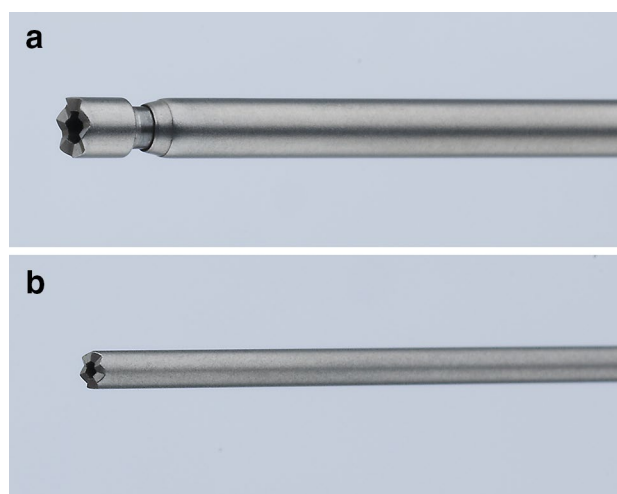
a Tip of Calcuson® lithotripter ultrasound probe with movable portion. b Tip of Calcuson® lithotripter ultrasound probe without movable portion. (Courtesy of Karl Storz GmbH & Co. KG)
